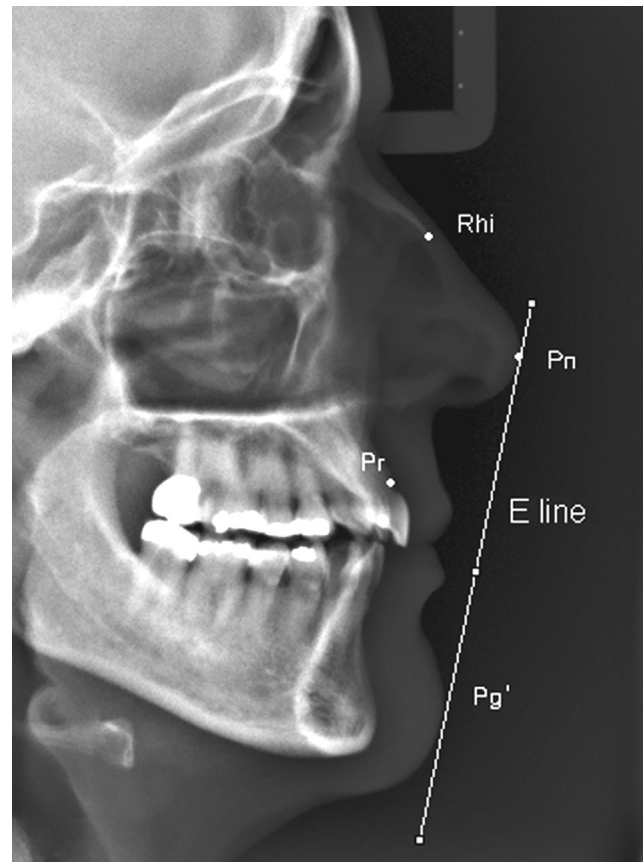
Pr, Pn and Rhi points on the cephalometric radiograph.
